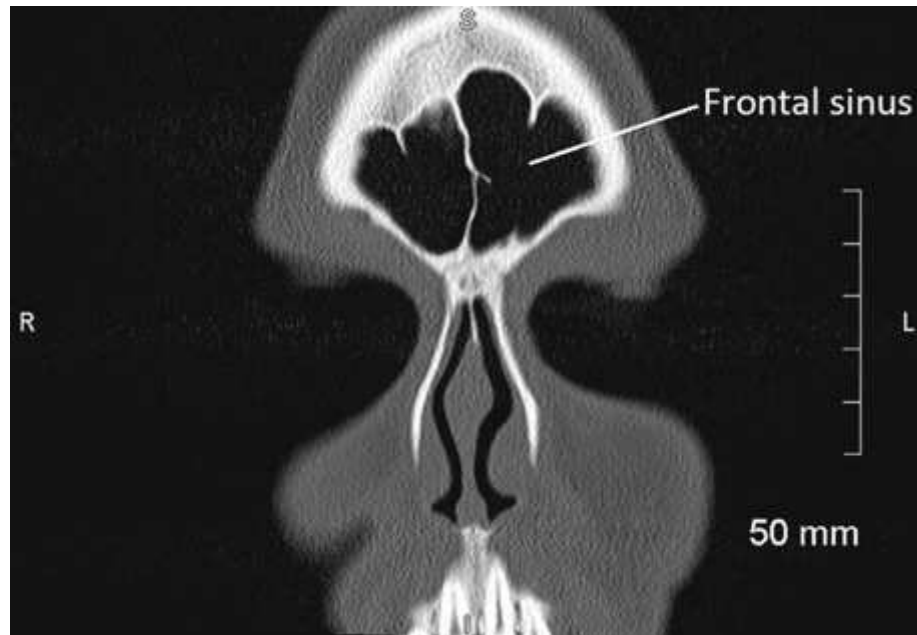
Coronal CT image of frontal sinuses. Courtesy Heath Yarbrough, RT[R][MR][CT], NEA Baptist Memorial Hospital, Jonesboro, AR.
